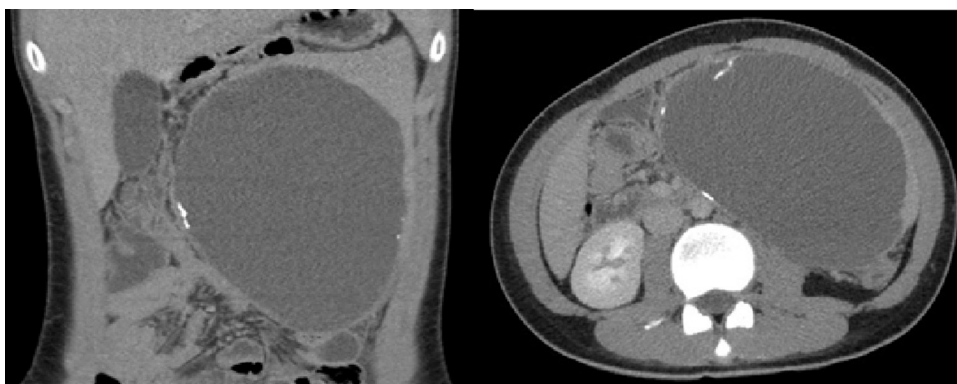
CT scan images of a large cystic lesion arising from the lower pole of the mildly enlarged spleen with rim calcification.
